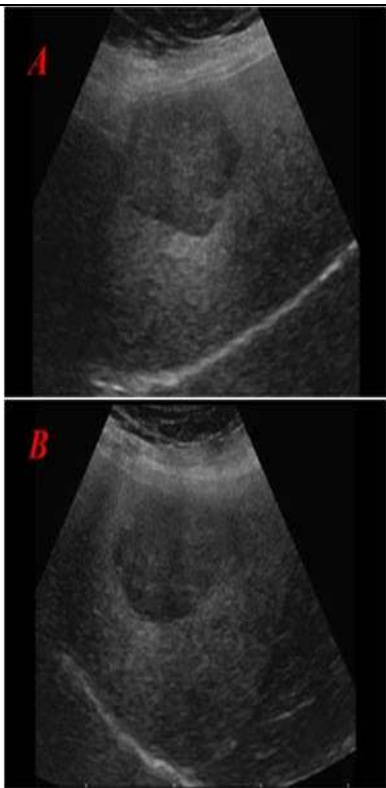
Sample images of HEM class from ultrasoundcases.info [2] (a), (b) contains solitary lesions and (c) contains 2 lesions.
